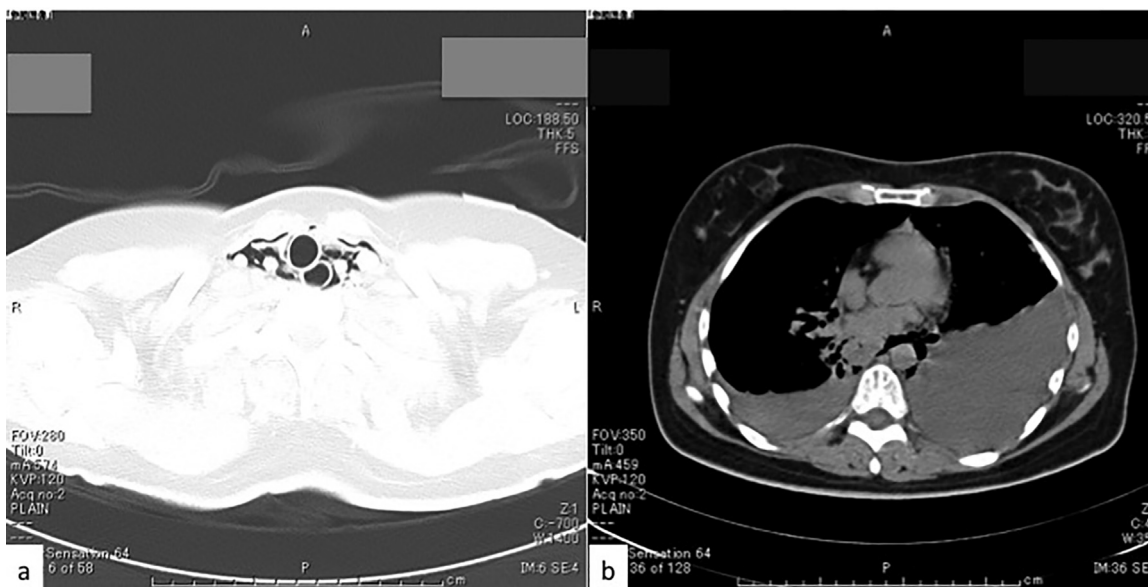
a. At initial diagnosis, computed tomography scan revealed cervical subcutaneous emphysema. b. A large quantity of pleural fluid on the left side and mediastinal emphysema were detected.
